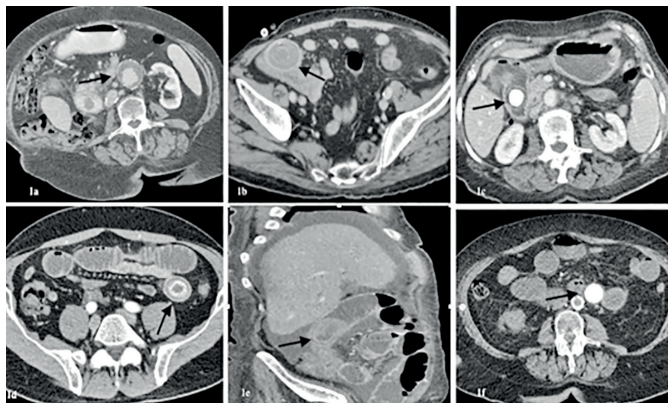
CT scan with IV and oral contrast showing (a) a solid mass in size of 3.5 cm embedded in the 3rd part of the duodenum (white arrow) in case 1, (b) a gallstone impacted in the jejunum in case 2, (c) a solid mass impacted in the first part of the duodenum, as well as air into the gallbladder and the biliary tree in case 3, (d) a solid mass obstructing the ileum in case 4, (e) ileal obstruction caused by a solid mass in case 5, (f) jejunal obstruction in case 6.
